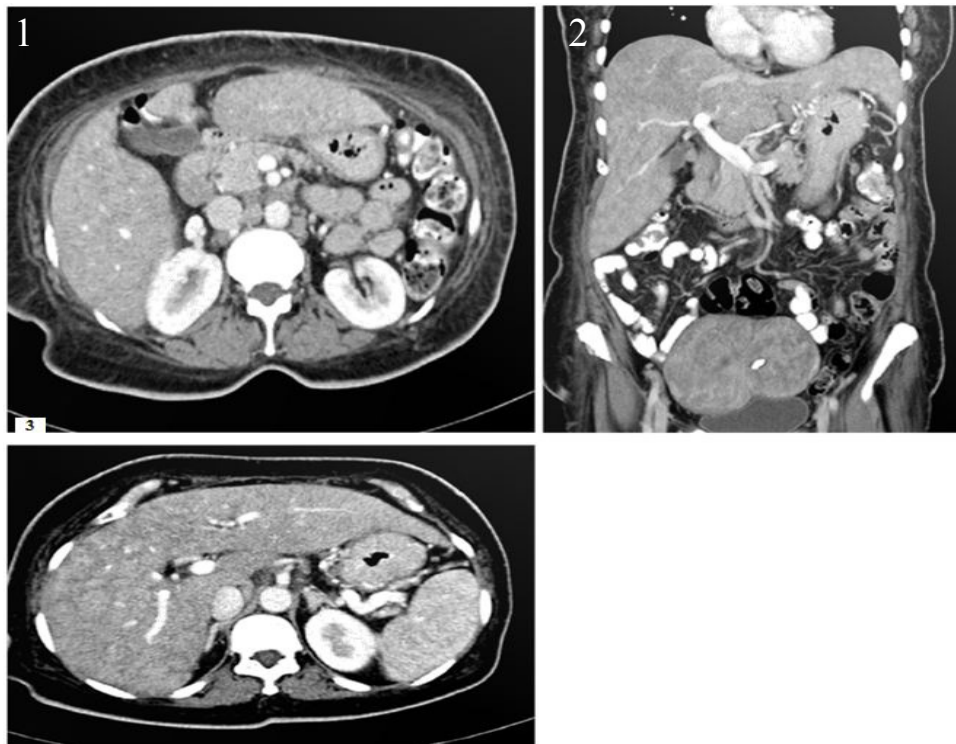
2 & 3: CT scan abdomen showed enlarged hepatoduodenal, paracava and paraaortic lymphadenopathy along with uterine fibroid.
